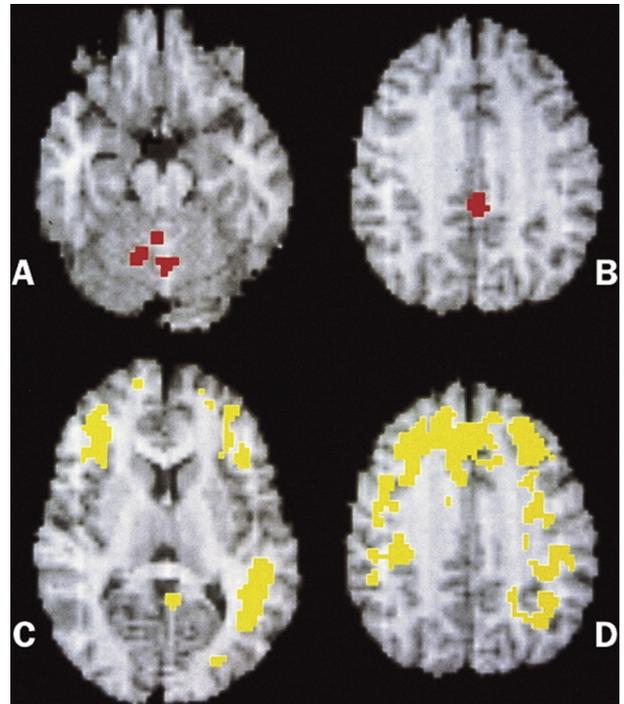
Brain images of the 17-year-old patient during a sleepwalking episode as recorded in real time by single photon emission computed tomography. The highest increases of regional cerebral blood flow (>25%) during sleepwalking compared with quiet stage 3–4 non-rapid eye movement sleep are found in the anterior cerebellum (A) and in the posterior cingulate cortex (B). However, in relation to data from normal volunteers during wakefulness ($n = 24$), large areas of frontal and parietal association cortices remain deactivated during sleepwalking, as shown in the corresponding parametric maps. Note the inclusion of the dorsolateral prefrontal cortex (C), mesial frontal cortex (D), and left angular gyrus (C) within these areas. From "SPECT During Sleepwalking," by C. Bassetti, S. Vella, F. Donati, P. Wielepp, and B. Weder, 2000, *The Lancet*, 356, p. 485. Copyright 2000 by Elsevier.
